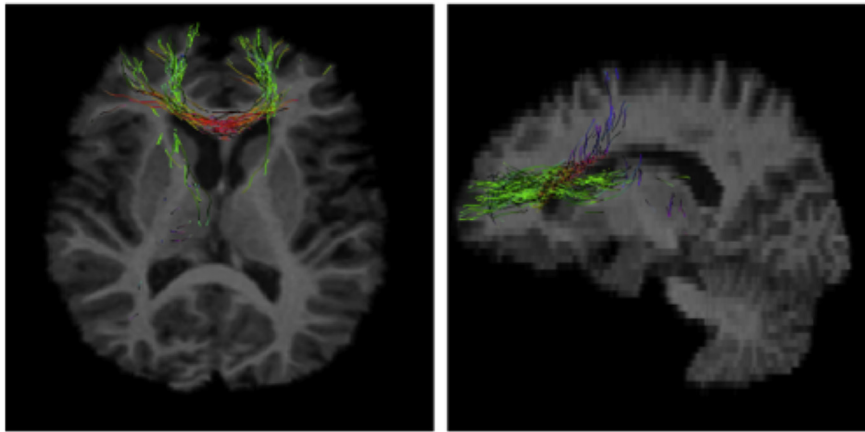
Global tractography using seed regions in which change in fractional anisotropy correlated positively with change in plasma phospholipid docosahexaenoic acid as a percentage of total plasma phospholipid PUFAs (DHA%) for major depressive disorder. Tractography results from one representative healthy volunteer are shown here, superimposed on the same individual's structural MRI. Red – left to right; blue – inferior to superior; green – anterior to posterior.
